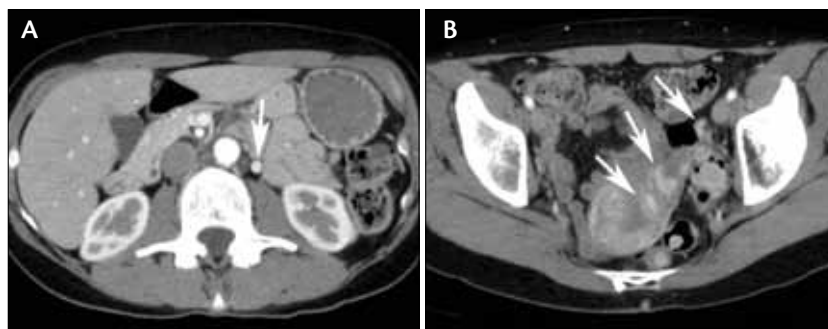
Left ovarian varices. Preprocedural axial-enhanced CT image through the abdomen demonstrates a dilated left ovarian vein (arrow, A). CT through the pelvis delineates the left pelvic varices (arrows, B).
